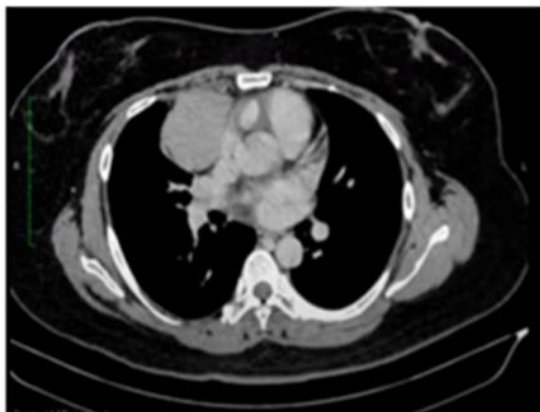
Spiral chest CT scan showing anterior mediastinal mass
